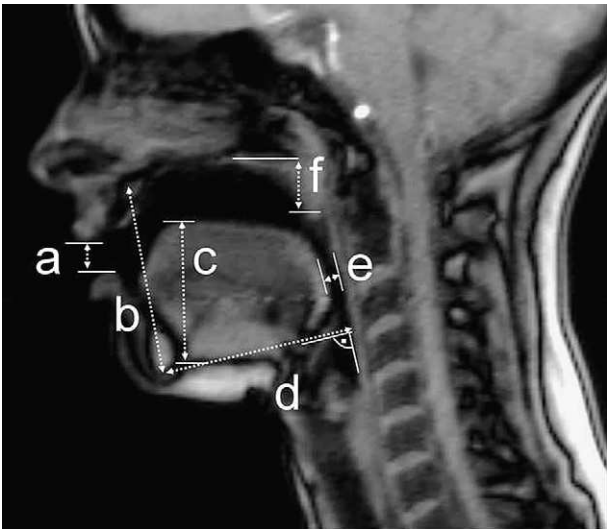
Distances measured in the evaluation of the MRI material: (a) lips, (b) jaw opening, (c) tongue dorsum, (d) jaw protrusion, (e) oropharynx width, and (f) uvula elevation.
